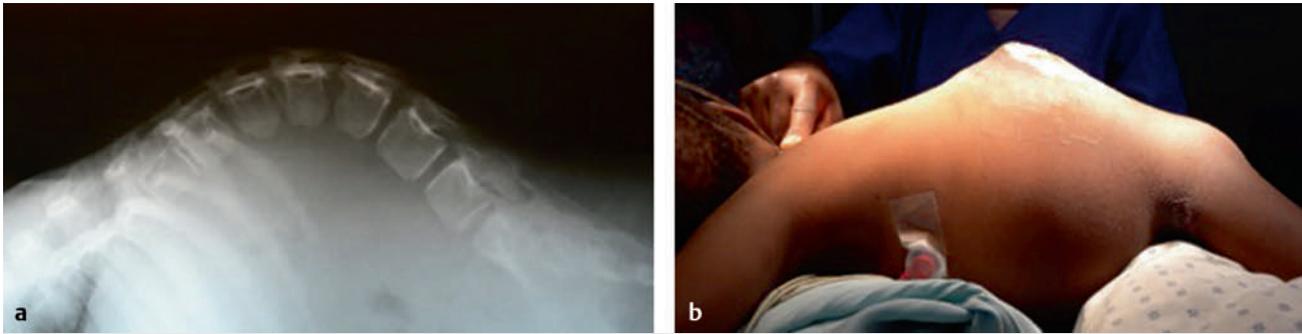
Lateral spine radiographs of (a) an infant with a congenital kyphotic deformity associated with a myelomeningocele and (b) a 2-year-old child with a myelomeningocele-kyphotic deformity that was unrepaired at birth.
